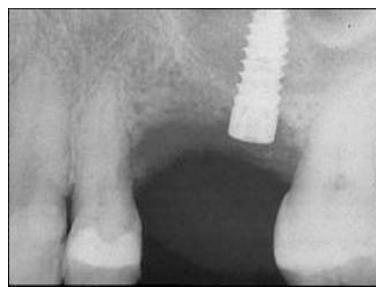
Radiography 4 months later shows good osseointegration together with new bone formation
